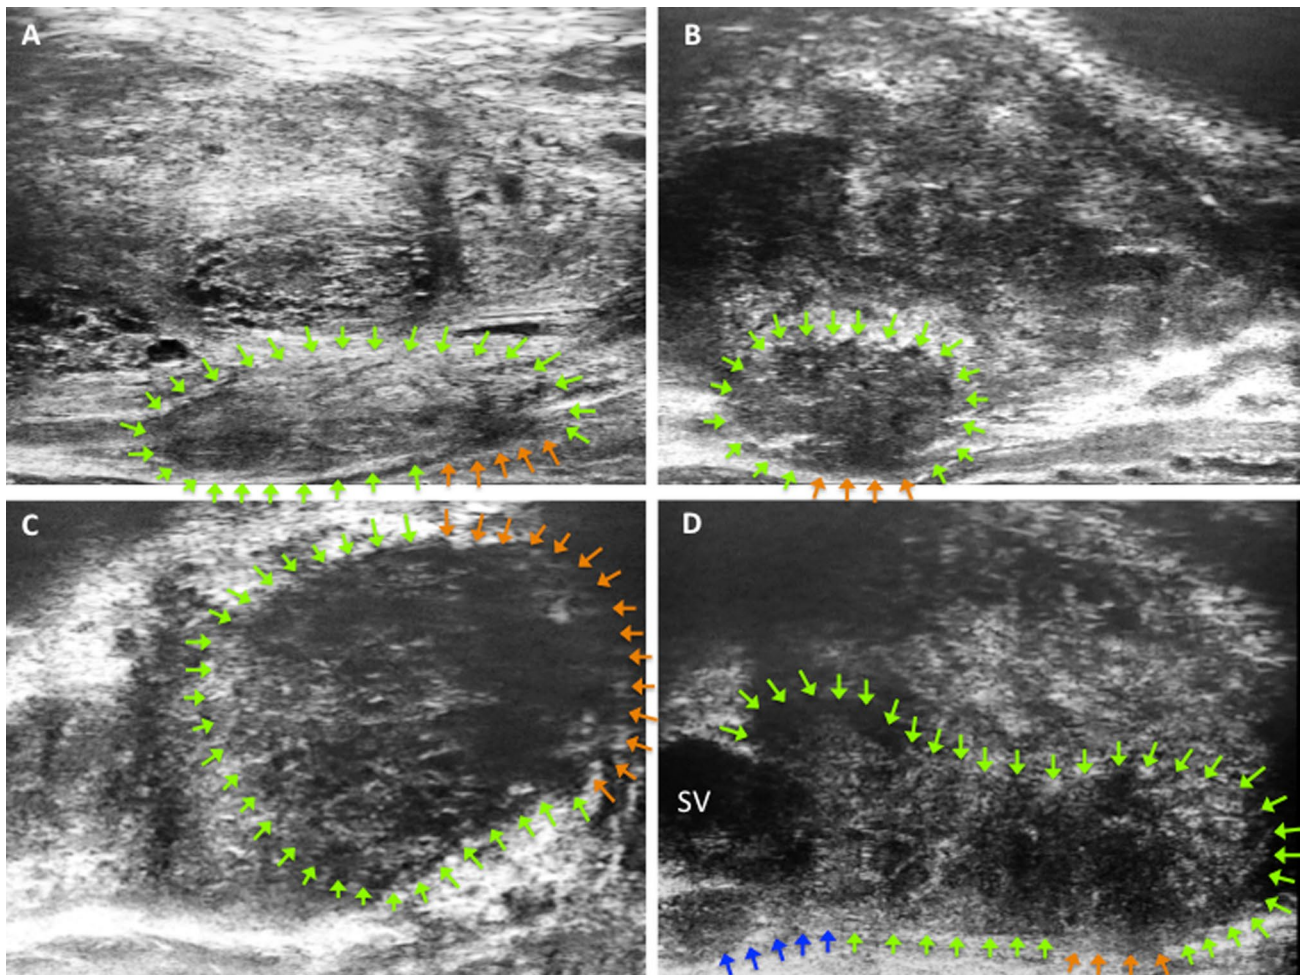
Micro-ultrasound showing: A mixed-echo lesion (PRIMUS V; green arrows) and a visible capsular breach at the level of the apex (orange arrows); B smudgy lesion (PRIMUS IV; green arrows) with capsular bulging and visible capsular breach at the base of the prostate (orange arrows); C smudgy lesion (PRIMUS IV; green arrows)
